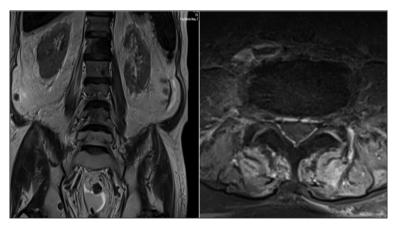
Magnetic resonance imaging images of the patient with plexus involvement before radiotherapy.
